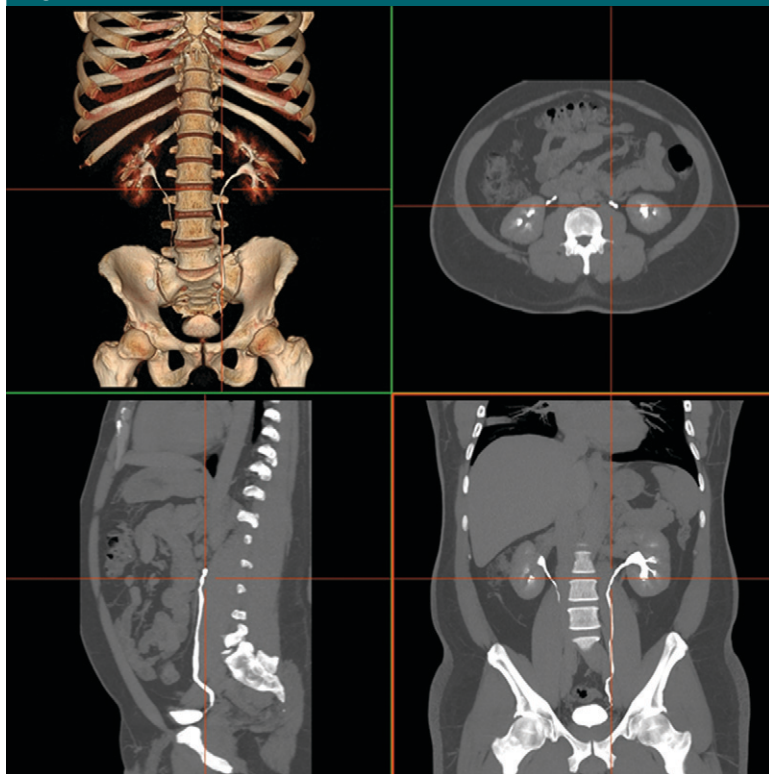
Screenshot of graphical user interface for viewing CT urograms. Top left: 3D volume-rendered image. Top right: Axial multiplanar reformation. Bottom left: Sagittal multiplanar reformation. Bottom right: Coronal multiplanar reformation. (Images courtesy of Luciano M. Prevedello, MD, Brigham and Women's Hospital, Boston, Mass.)
